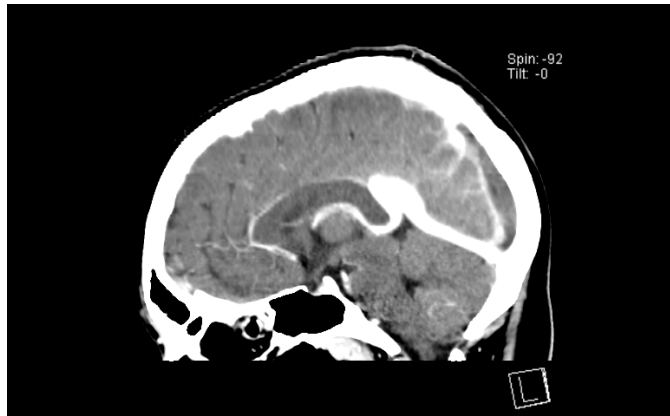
CT brain with contrast showing thrombosis of posterior aspect of superior sagittal sinus
